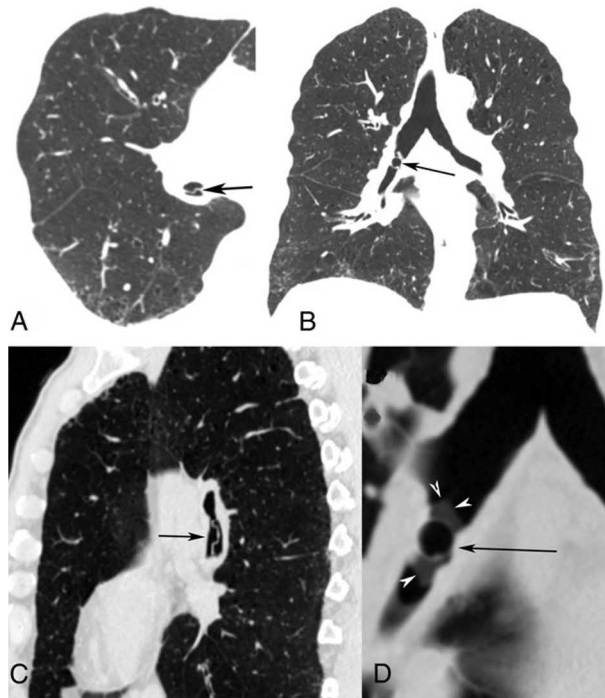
CT images showing a radiopaque blister pack in the right intermediary bronchus (arrows). A, Axial. B, Coronal. C, Sagittal. D, Coronal magnification showing the borders of the blister pack (arrowheads).
